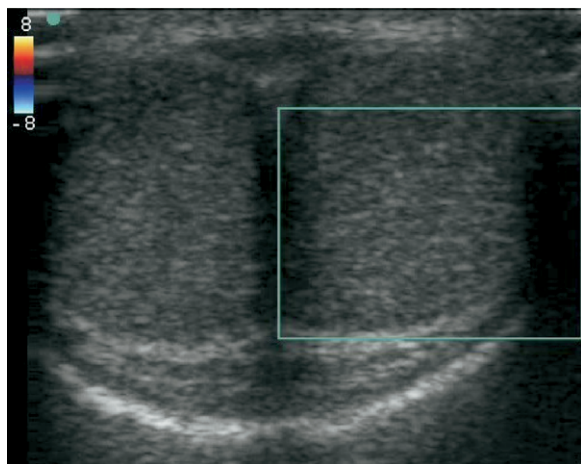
Color Doppler ultrasound of penis pretreatment.
